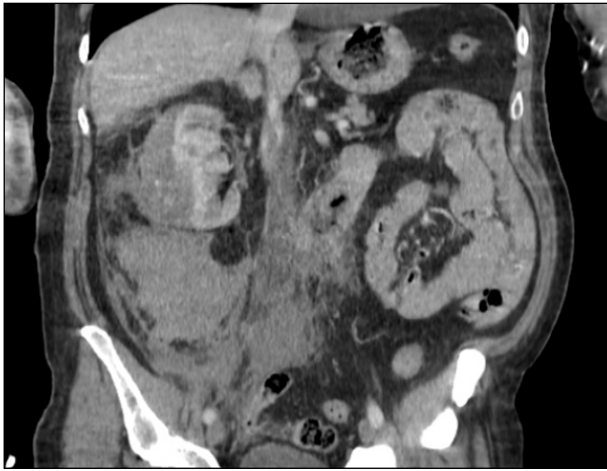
Contrast-enhanced computed tomography image in the emergency department (coronal section)
